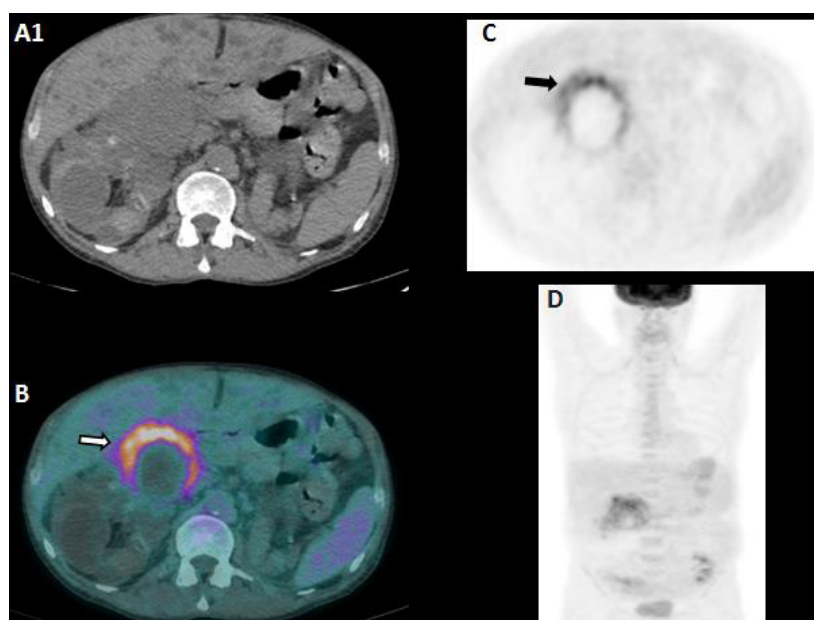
A–D. Axial CT (A), axial PET (B) and axial PET/CT (C) displays one renal cyst with ring shape of the wall FDG avid in the right kidney. Maximum intensity projection, MIP, shows no other pathological uptakes in the remaining body studied (D)
